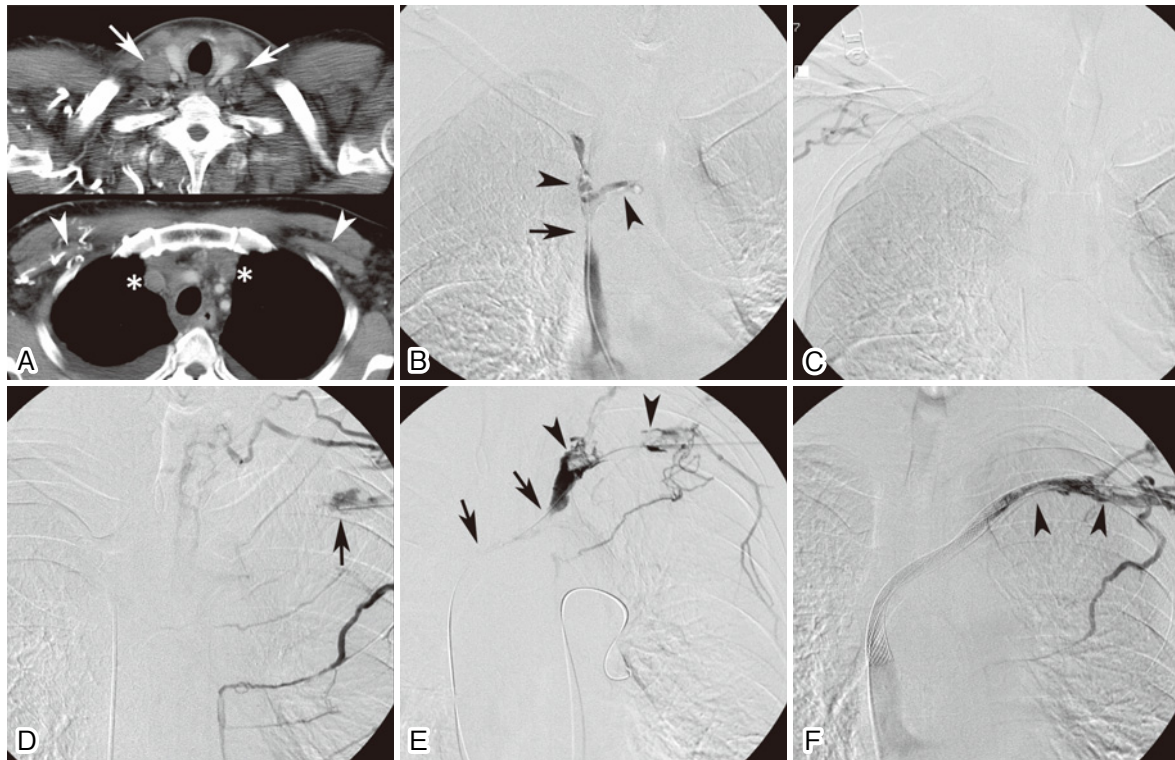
Endovascular treatment for superior vena cava (SVC) syndrome due to lung cancer and massive thrombi. A. The patient presented with face, neck, and upper-extremity edema. Contrast-enhanced CT showed massive thrombi in the bilateral subclavian (arrowheads), internal jugular (arrows), and brachiocephalic veins (asterisks) and bilateral pleural effusion. SVC was also obstructed by mediastinal lymph node metastases (not shown). B. A catheter was advanced into SVC via the right femoral vein, and a venogram showed severe stricture of SVC (arrow) and thrombi in the bilateral brachiocephalic veins (arrowheads). C. A venogram via the right median cubital vein showed that the right axillary vein was not opacified. D. Contrast-enhanced CT showed that the left axillary vein was partially opened (not shown). Therefore, the left median cubital vein was punctured and another catheter was advanced into the left subclavian vein, and a venogram showed complete occlusion of the left subclavian vein. The arrow indicates a catheter tip in the left subclavian vein. E. The occluded segment (arrows) was then crossed by a conventional technique via the left brachial route. The arrowheads indicate massive thrombi. The guidewire was withdrawn from the sheath in the right femoral vein, and through-and-through access could be established (not shown). After thrombolysis using 480,000 U of urokinase and thromboaspiration using a 6-F thromboaspiration catheter, two Wallstents (14 × 90 and 12 × 90 mm, respectively) were placed from SVC to the left subclavian vein via the right femoral route. The stents were then dilated using a 10-mm-diameter balloon catheter (not shown). F. The final venogram showed rapid blood flow through the stent, although residual thrombi (arrowheads) were seen in the stent lumen.
